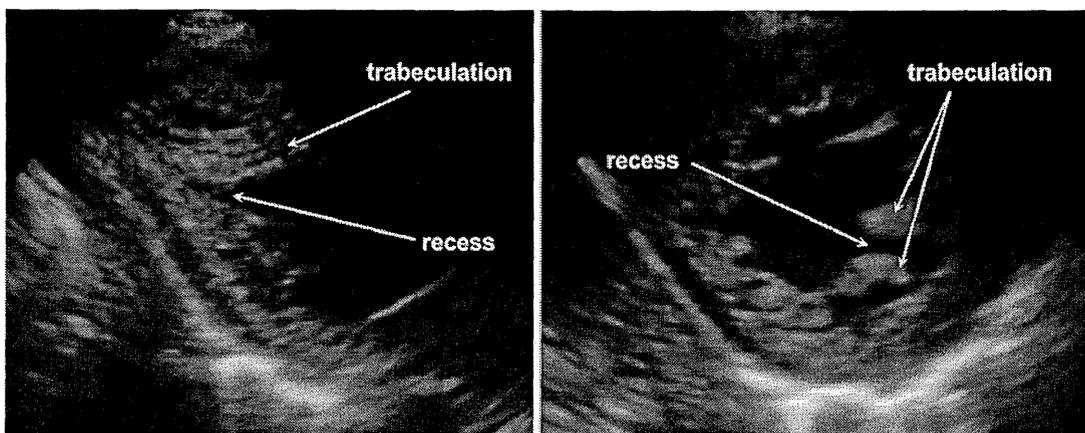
Echocardiogram. Prominent trabeculations and a deep recess were detected
